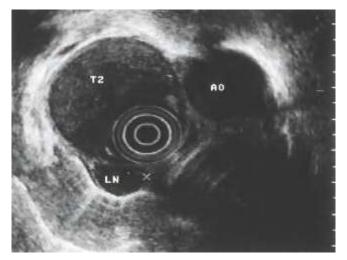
Endosonography demonstrating malignant nodes. These are usually large, hypoechoic and round compared with normal nodes.
